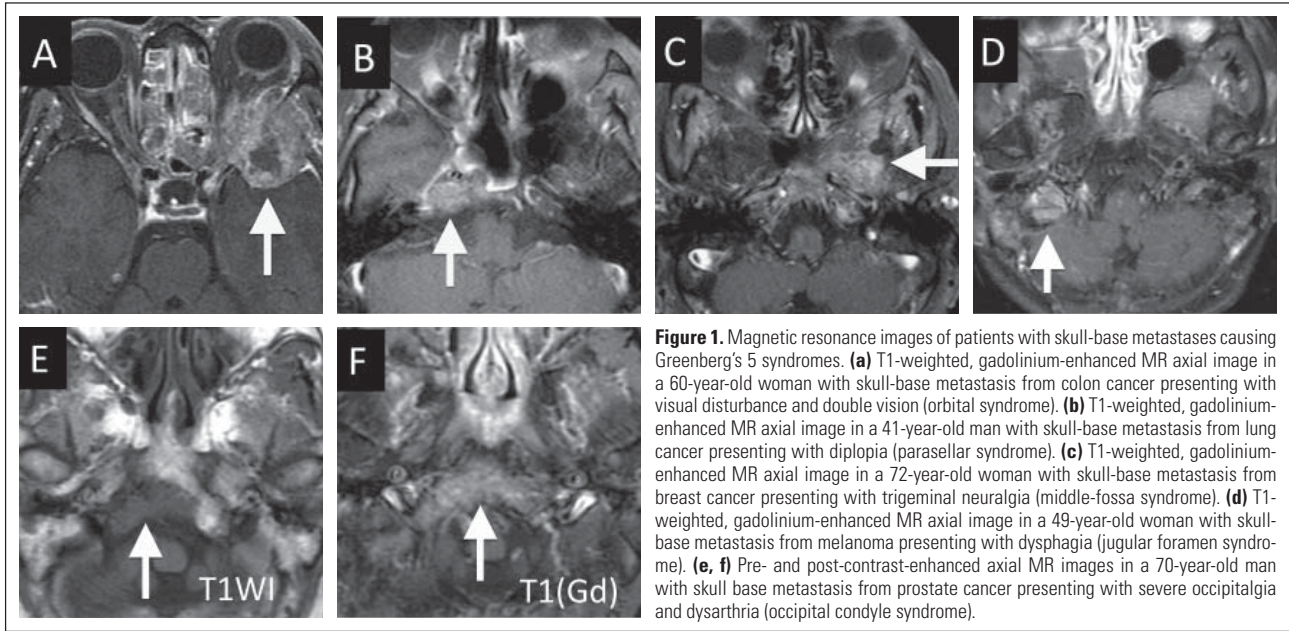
Magnetic resonance images of patients with skull-base metastases causing Greenberg's 5 syndromes. (a) T1-weighted, gadolinium-enhanced MR axial image in a 60-year-old woman with skull-base metastasis from colon cancer presenting with visual disturbance and double vision (orbital syndrome). (b) T1-weighted, gadolinium-enhanced MR axial image in a 41-year-old man with skull-base metastasis from lung cancer presenting with diplopia (parasellar syndrome). (c) T1-weighted, gadolinium-enhanced MR axial image in a 72-year-old woman with skull-base metastasis from breast cancer presenting with trigeminal neuralgia (middle-fossa syndrome). (d) T1-weighted, gadolinium-enhanced MR axial image in a 49-year-old woman with skull-base metastasis from melanoma presenting with dysphagia (jugular foramen syndrome). (e, f) Pre- and post-contrast-enhanced axial MR images in a 70-year-old man with skull base metastasis from prostate cancer presenting with severe occipitalgia and dysarthria (occipital condyle syndrome).
